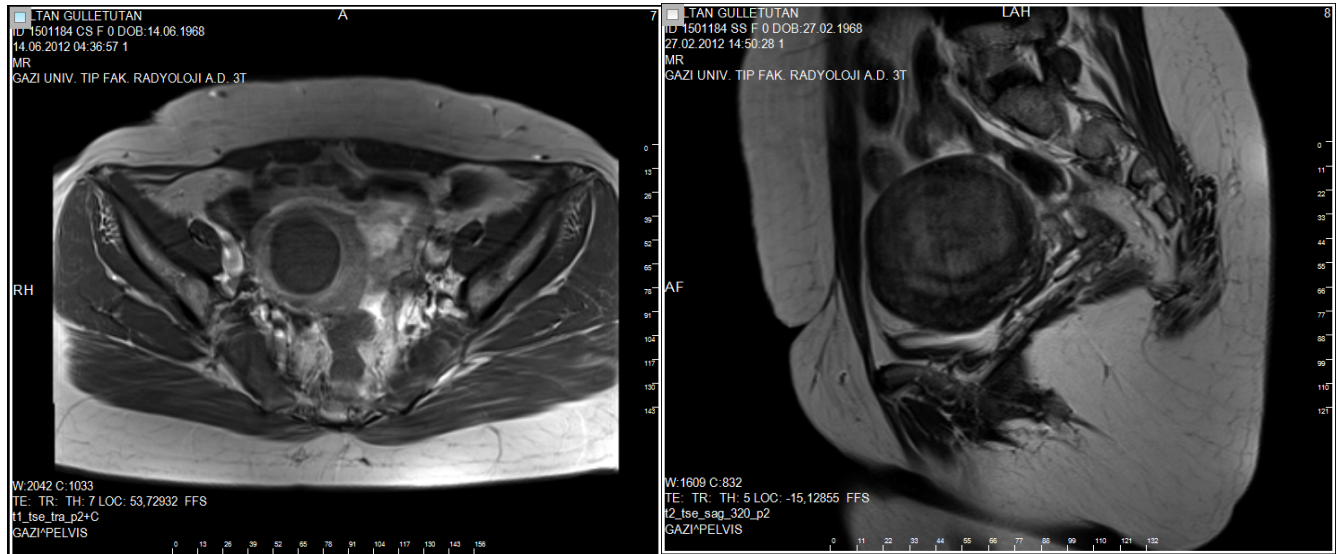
Patient SG: MR image of the pre and post-embolization leiomyoma.
